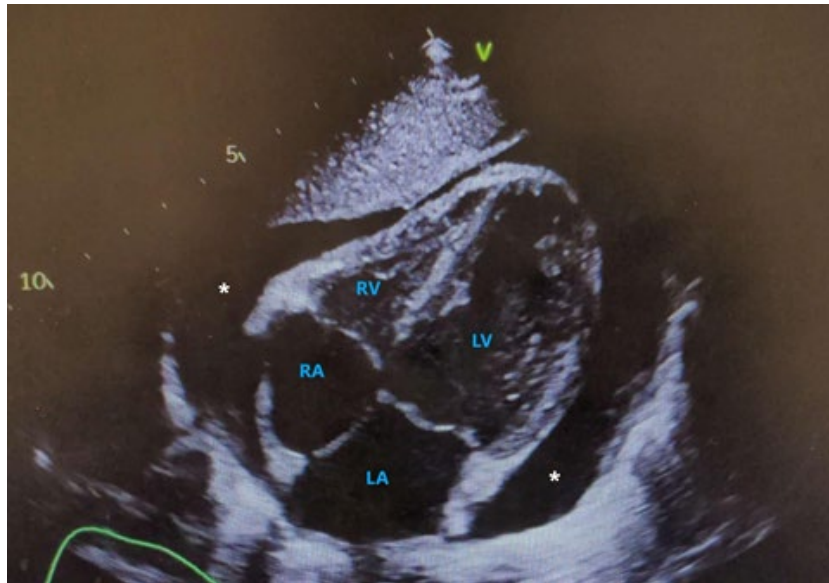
Subcostal four chamber view of the heart by echocardiogram, showing pericardial effusion as indicated by the asterisks.
